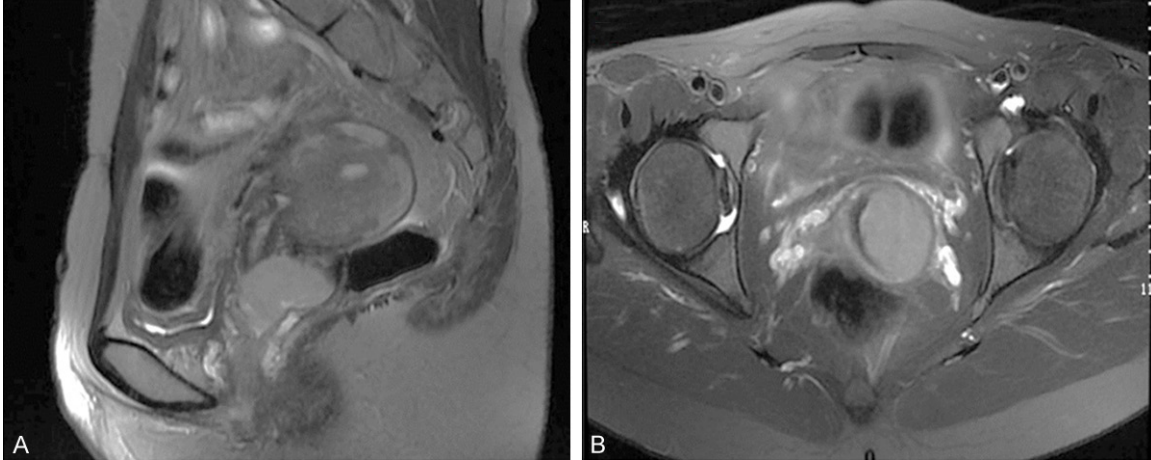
MRI images of a 40-year-old female. There was lymphovascular infiltration and deep interstitial infiltration. A. Lateral view; B. Anteroposterior view.
